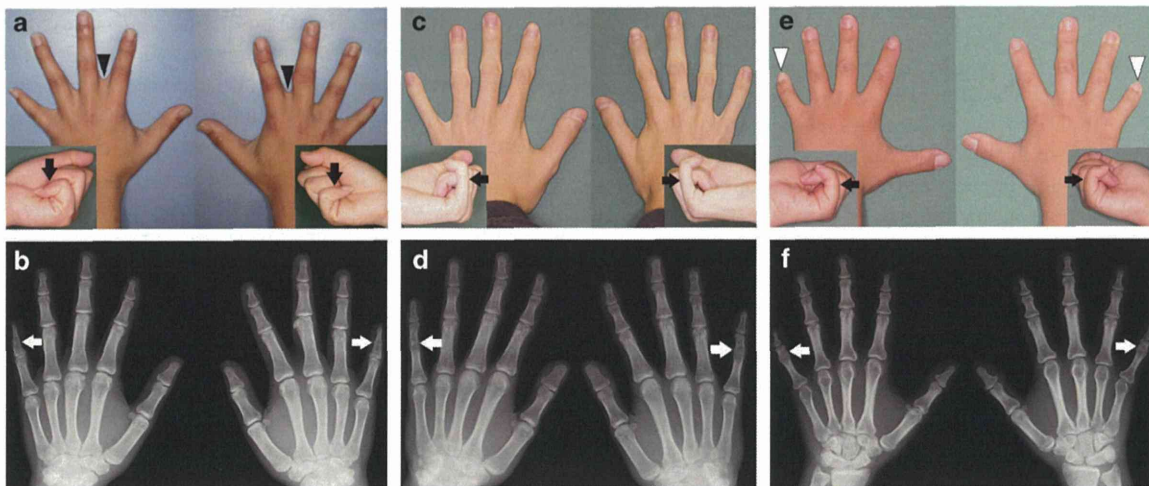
Views and radiographs of the patients' hands. (a, b) Patient 1, (c, d) patient 2 and (e, f) patient 3. (a, c, e) Views of hands and (b, d, f) radiographs of hands. Black arrows indicate symphalangism in (a) the distal interphalangeal joint and (c, d) proximal interphalangeal joint of the fifth fingers. Black arrowheads indicate cutaneous syndactyly. White arrowheads indicate short fifth fingers (brachydactyly).
